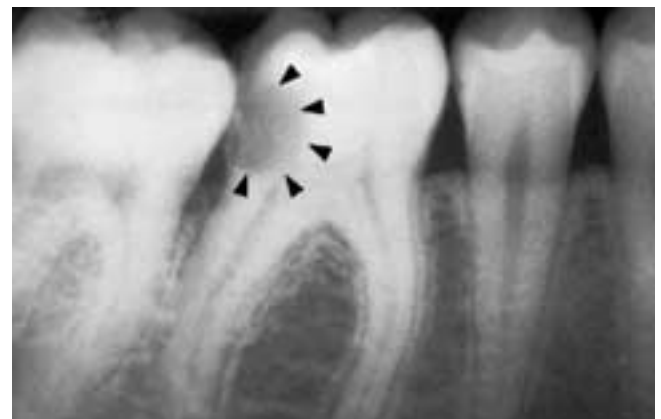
Bitewing radiograph of the mandibular second molar shows large interproximal carious lesion on the distal surface (*arrowheads*). Note that the root apices are not in the field of view on the bitewing radiograph.
